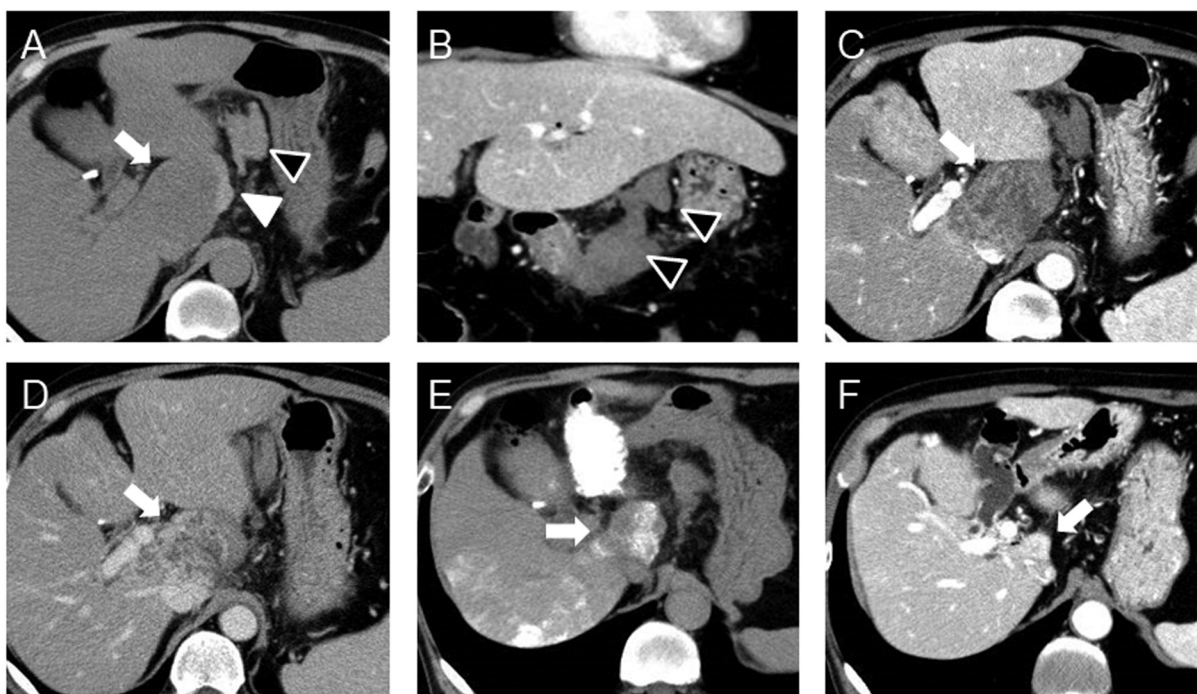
Serial abdominal computed tomography (CT) images. (A) Plain, (B) coronal portal venous phase, (C) arterial phase, and (D) delayed phase. Plain CT 4 days after the 2nd transarterial chemoembolization (TACE) (E). Follow-up CT after 3 months in portal venous phases (F). The liver tumor is indicated with arrows. The subcapsular hemorrhage and hemorrhage inside the omental bursa cavity are indicated as high-density areas, pointed out with white and black arrowheads, respectively (A). The tumor was gradually enhanced (B, C). Plain CT after TACE showed heterogeneous hyperdensity representing lipiodol deposition (D). Follow-up CT after 3 months showed homogeneous enhancement of the tumor in arterial and portal venous phases (E, F).
